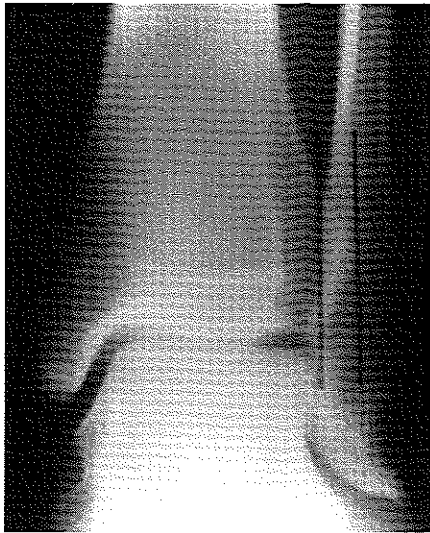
The tibiofibular overlap is defined by the horizontal distance from the medial border of the fibula to the lateral border of the anterior tibial prominence on the anteroposterior or mortise radiograph. The measurement is taken approximately 1 cm proximal to the ankle joint.
